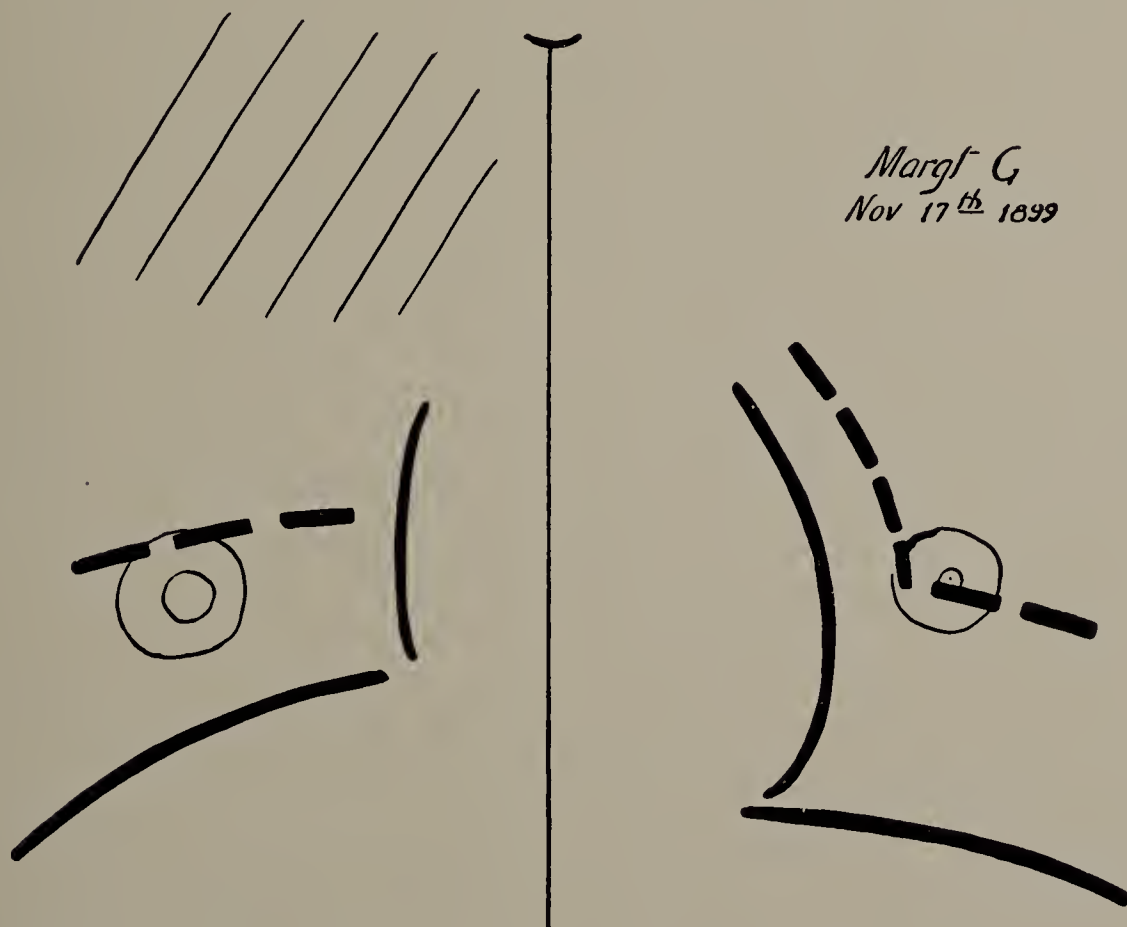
Margaret G. X-ray tracing made November 17, 1899. (One-third life size.) Right apex darker than normal; excursion of diaphragm shortened on right side as compared with the left.
